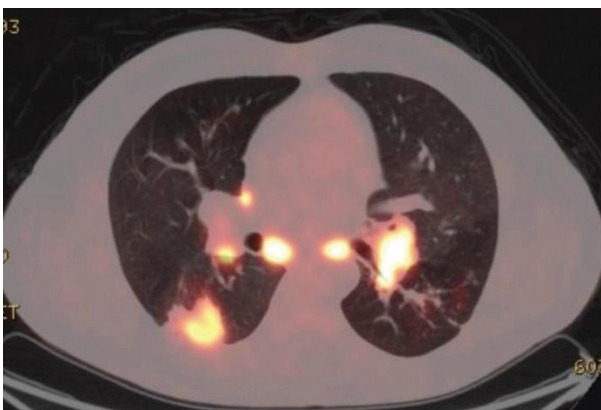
4-centimeter-mass lesions in both lung parenchyma with 16 mSUV, multiple mediastinal lymphadenopathies with 15 mSUV
